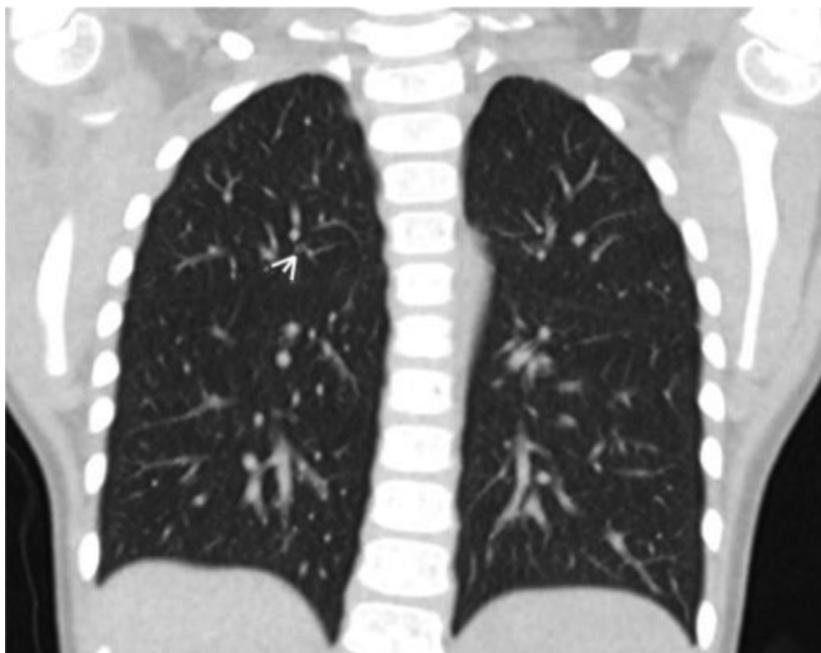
Computed tomography scan of the patient's chest without contrast. There was diffuse but mild nonspecific peribronchovascular thickening, with one such area of peribronchovascular thickening highlighted (arrow). There was no evidence of interstitial lung disease.
